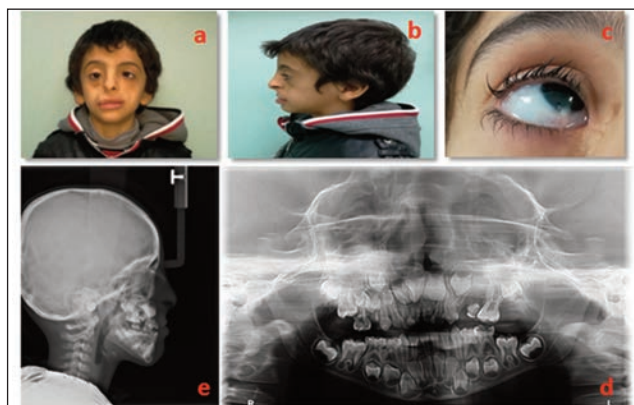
Extra-oral pictures (a) straight, (b) profile view, (c) coloboma of the eye, (d) orthopantomogram, and (e) lateral cephalogram of a child with Goldenhar Syndrome.
